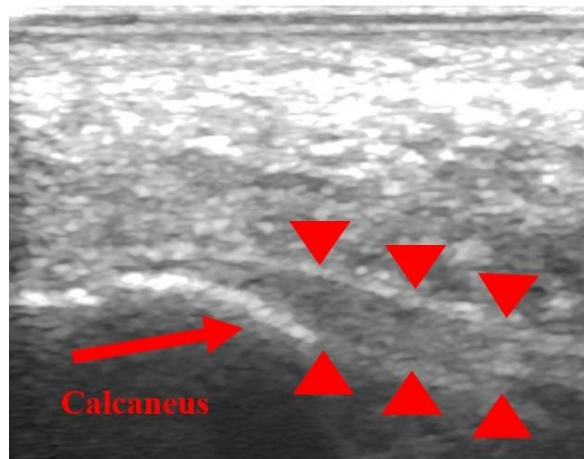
Representation of a B-mode ultrasound image to measure PF thickness at the proximal site.
